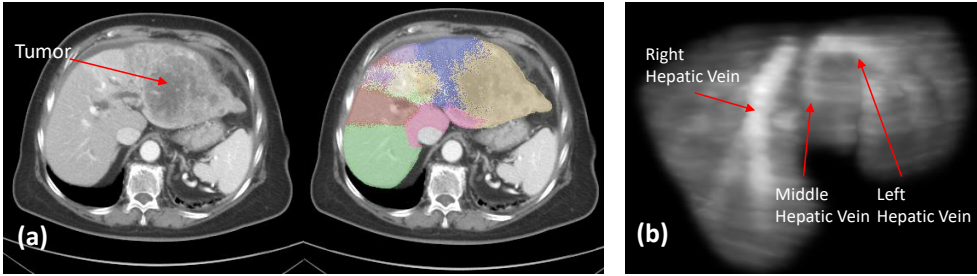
Failure case analysis. (a) The anatomical landmarks disappear in the tumor region marked by the red arrow. (b) Output of  $\mathcal{G}_r(f(\mathbf{p}))$  of a successful case. The model learns the graph affinities based on the anatomical landmarks in the CT images.
